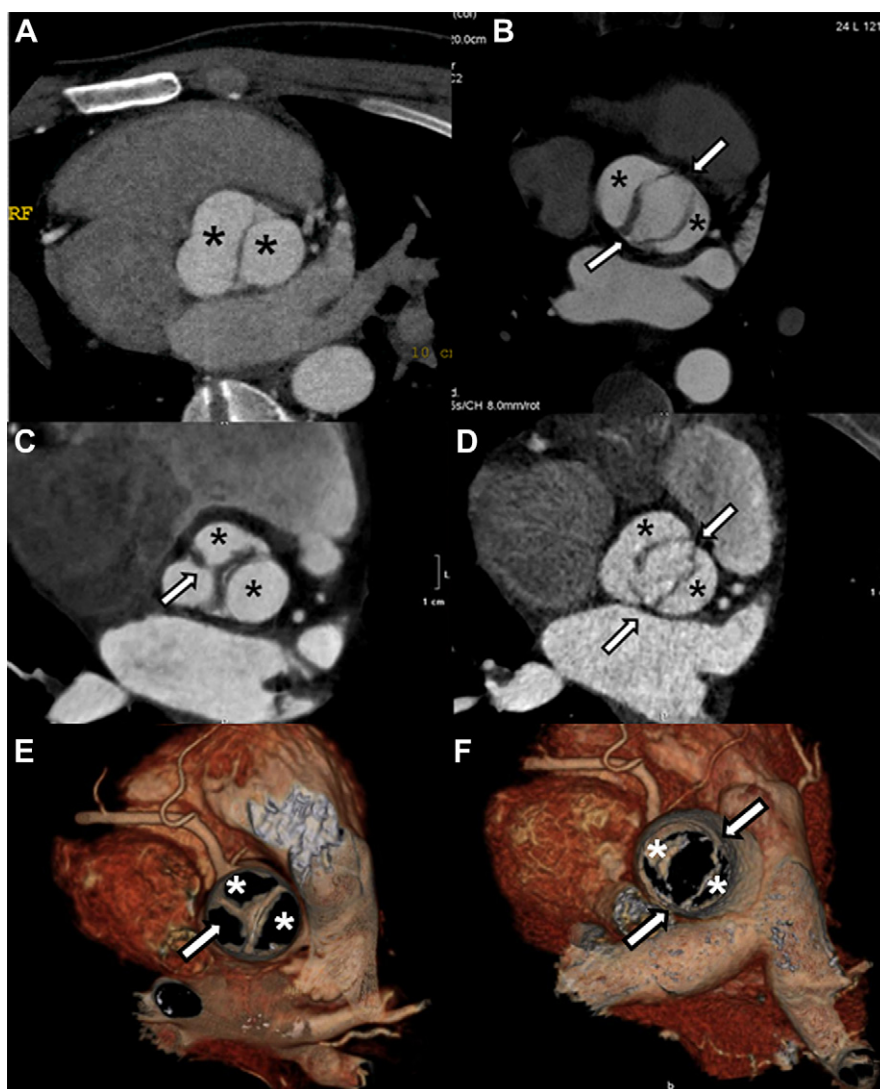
Multidetector computed tomography aortic valve short-axis views show congenital variants of bicuspid aortic valve morphologies. (A) Bicuspid aortic valve morphology with 2 aortic cusps seen (*asterisks*) in diastole. (B) Bicuspid aortic valve in systole, with 2 commissures defining the outline of the 2 cusps (*asterisks*). (C) Example of a bicuspid aortic valve with an initial trileaflet appearance in diastole, which reveals itself to be a bicuspid valve with a prominent raphe in systole. The 2 cusps are shown (*asterisks*) with the raphe (*arrow*) fusing the right and noncoronary cusps. (D) The bicuspid aortic valve in systole, with the 2 commissures (*arrows*) seen defining the 2 aortic cusps (*asterisks*). (E) Three-dimensional volume rendering of panel C, with the raphe (*arrow*) and 2 aortic cusps (*asterisks*) identified in diastole. (F) Three-dimensional volume rendering of panel D, with the 2 commissures (*arrows*) defining the 2 cusps (*asterisks*) in systole.
